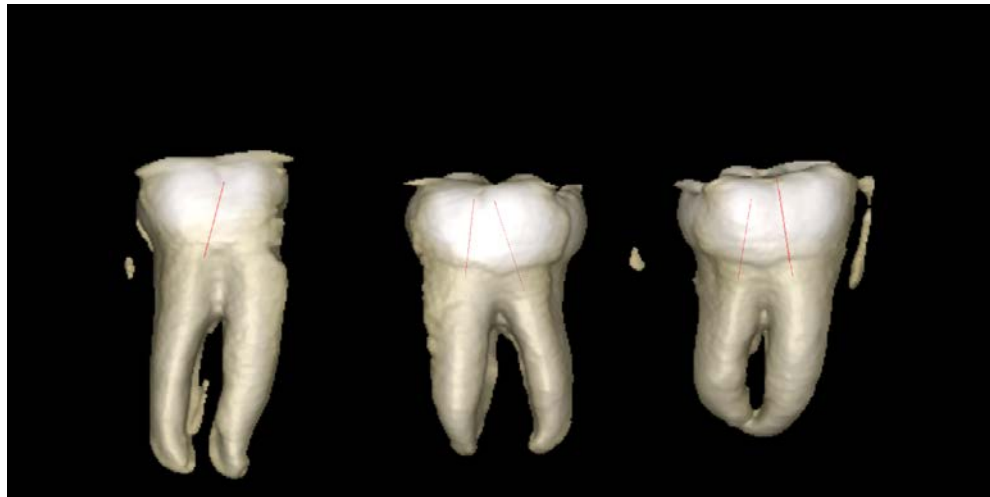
CBCT scan as viewed in Planmeca Romexis 3D model software.
